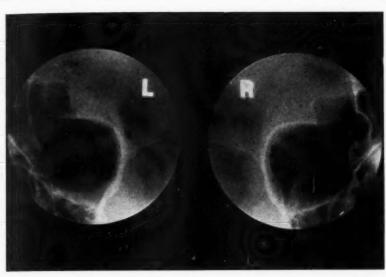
(Pfeiffer). Case 2. Roentgenogram of the optic canals, showing the large defect of the left side of the body of the sphenoid dividing the optic canal vertically. The right canal is normal.
